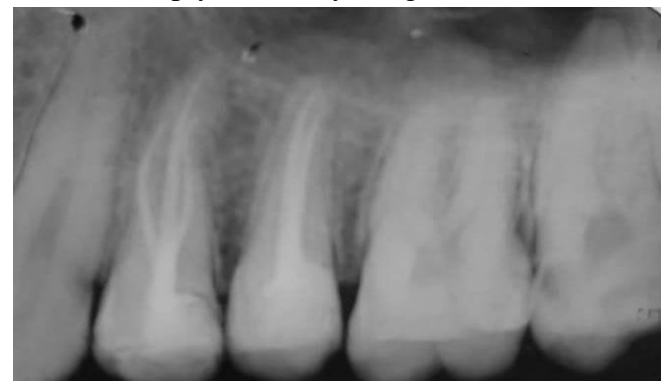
Post obturative radiograph
